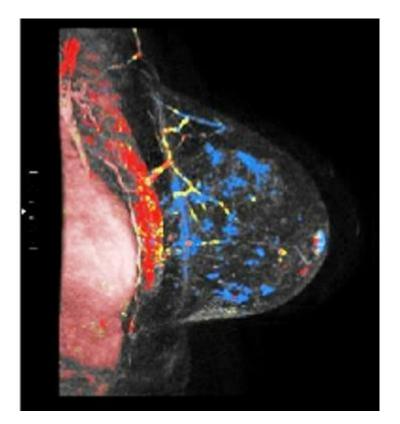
CAD assistance with interpretation of the sagittal left breast MRI image
